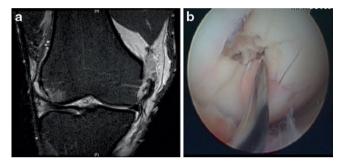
a T2 coronal MRI of right knee—observe the increased signal on the lateral femoral condyle which is suggestive of impaction of the lateral compartment following a valgus injury. b Arthroscopic image of the lateral femoral condyle in the same patient. Note the devastating cartilage injury as a result of impaction. *MRI* magnetic resonance imaging
